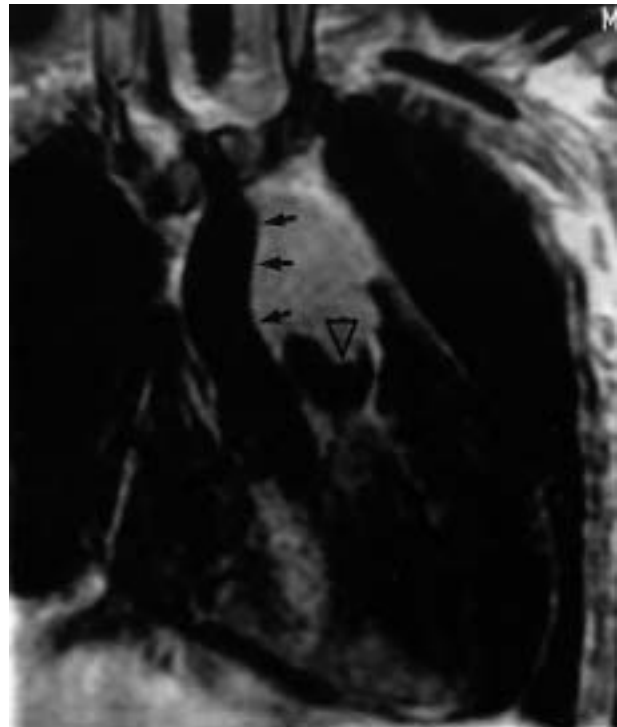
Coronal magnetic resonance imaging showing an adenocarcinoma in a young male infiltrating the aortopulmonary window. There is loss of the fat plane against the aorta (arrows) and invasion of the main pulmonary artery (arrowhead).
